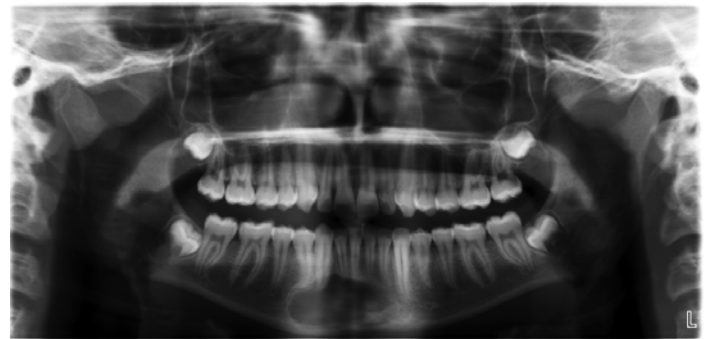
Panoramic radiograph allowed incidental finding of the periapical radiolucency involving apices of teeth #22-#28.
